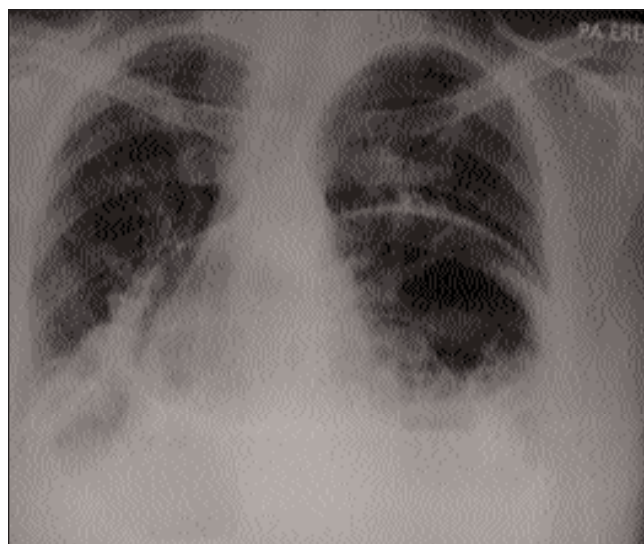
Chest radiograph showing a large hiatus hernia.
